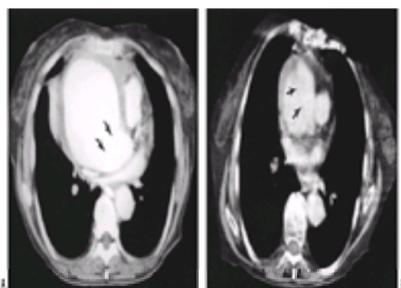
A: In many cases, dissection of the aorta is easily seen on contrast-enhanced CT, as demonstrated in this example. Here, a large saccular component of the aneurysm at the root of the aorta bulges anteriorly and to the right into the sinus of Valsalva. The intimal flap is visible as a thin, dark, obliquely oriented line (arrows) at the posterior aspect of the large, contrast-enhanced aortic root. Note that the attenuation of the region immediately surrounding the aorta is higher than that of fat and normal soft tissue and is caused by leakage of blood into the pericardial sac, a portion of which encompasses the aortic root. B: In another patient with aortic
